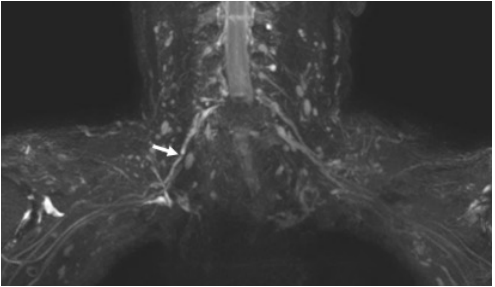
Brachial plexus MRI
